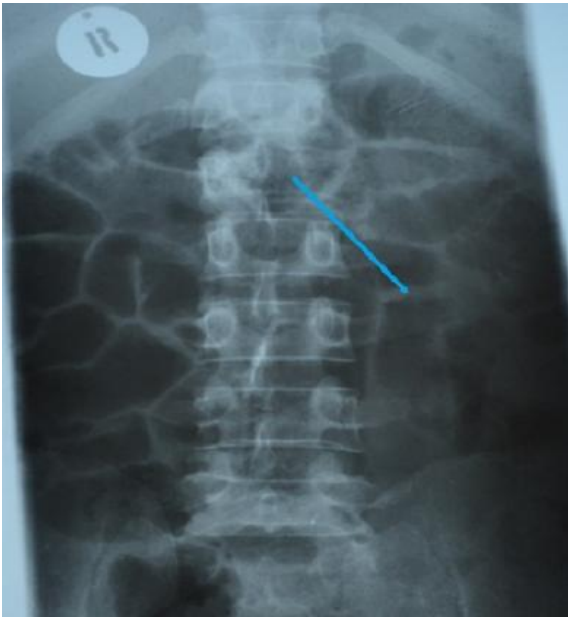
thoracic spine x-ray showing Osteolytic Left L1 lesion with missing pedicle (blue arrow)
